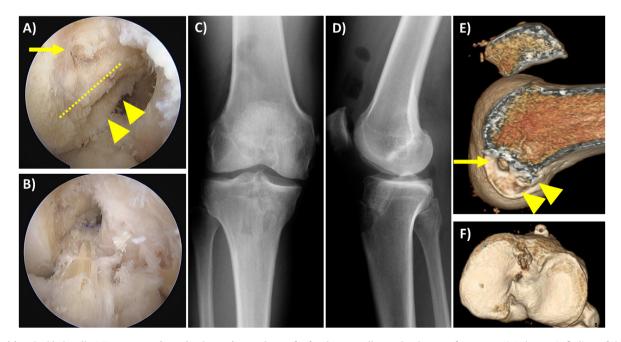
Revision double-bundle ACL reconstruction using hamstring tendon graft after bone-patellar tendon-bone graft rupture. A) Arthroscopic findings of the primary surgery screw hole (Arrow) and femoral tunnel of revision surgery (arrowhead) created behind the Resident's ridge (dotted line). B) Arthroscopic findings of revision ACL reconstruction. C, D) Postoperative anteroposterior and lateral radiographs. E, F) Femoral tunnel and tibial tunnel positions in postoperative 3-dimensional computed tomography.
